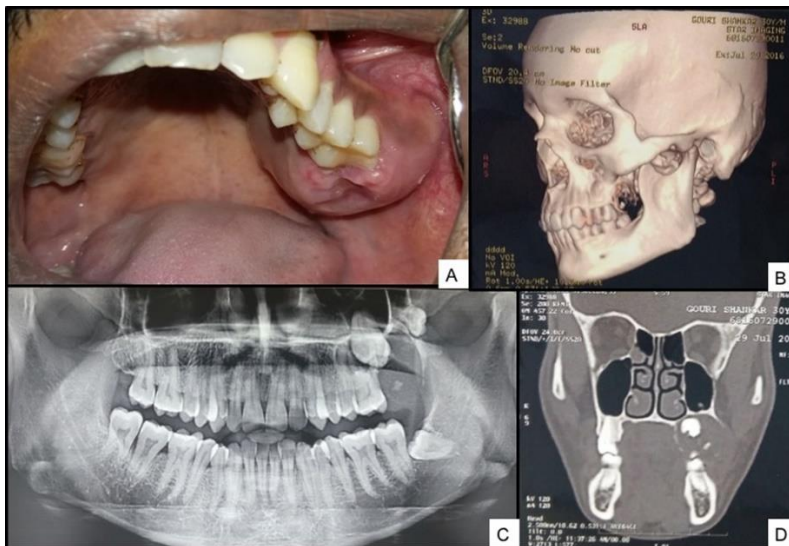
A) Intraoral photograph showing swelling in left posterior maxilla. B) 3D CT showing osteolytic lesion in left posterior maxilla. C) OPG showing unilocular radiolucency displacing 2nd and 3rd molars. Calcifications were also seen within the lesion. D) CT (coronal section) showing osteolytic lesion with perforation of cortical plate with impacted 2nd molar
